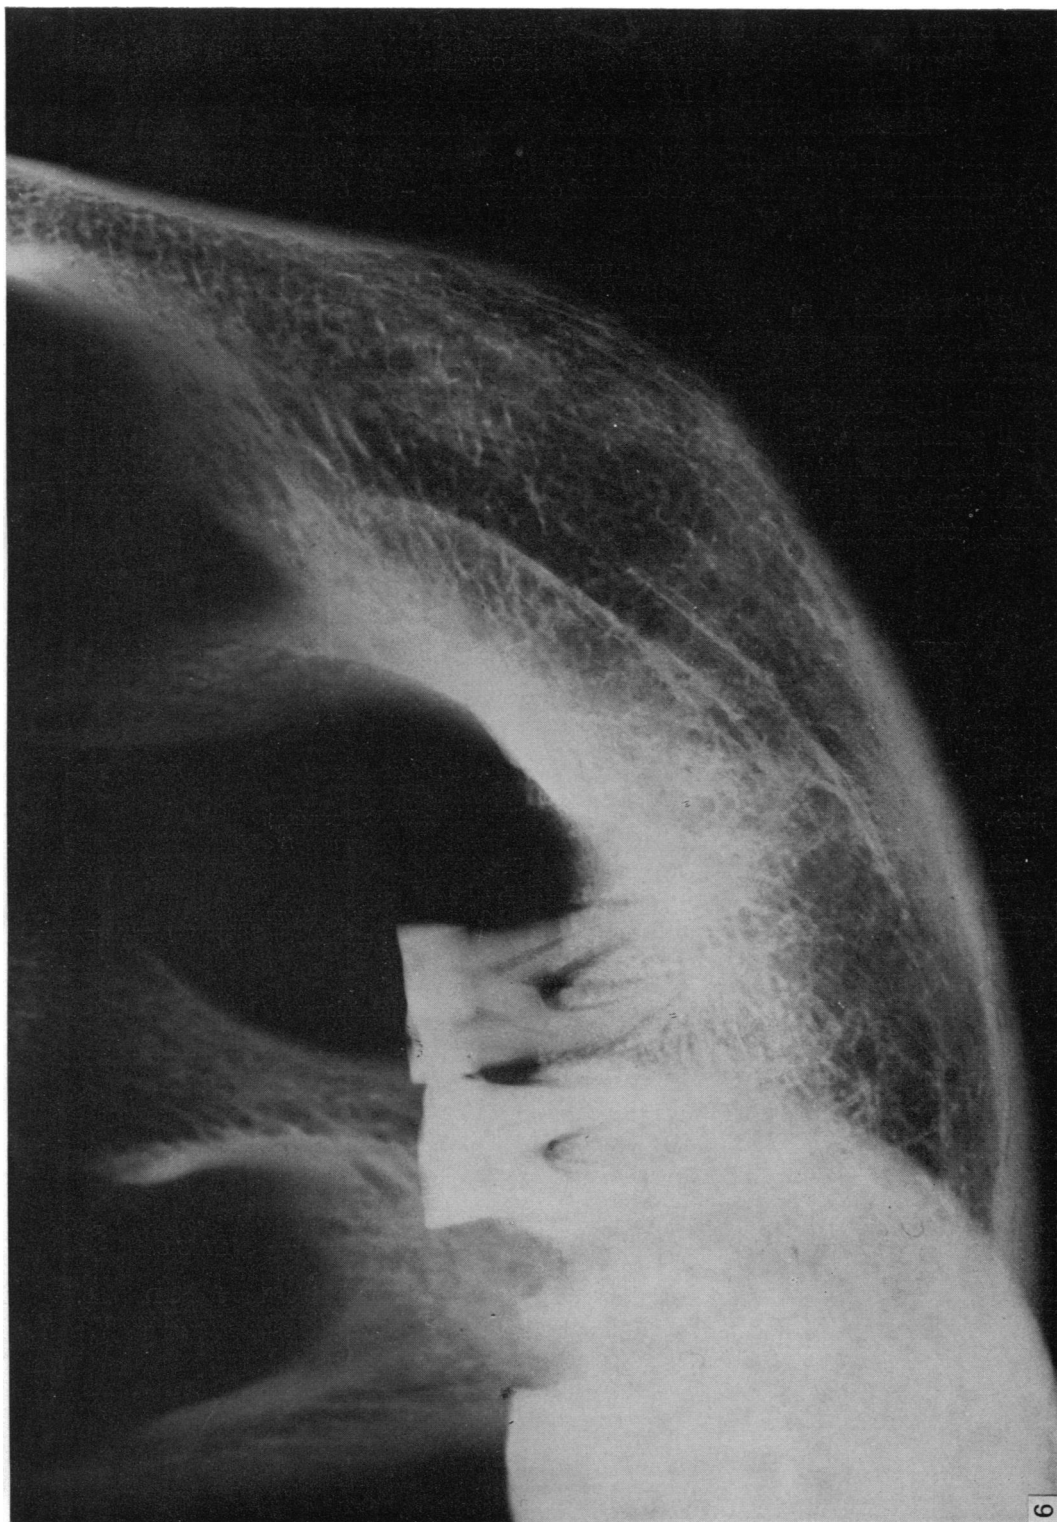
X-ray of the gonial region of a rocker jaw. The mandibular canal lies approximately midway between the borders of the bone, and there is no distinct angular process.
